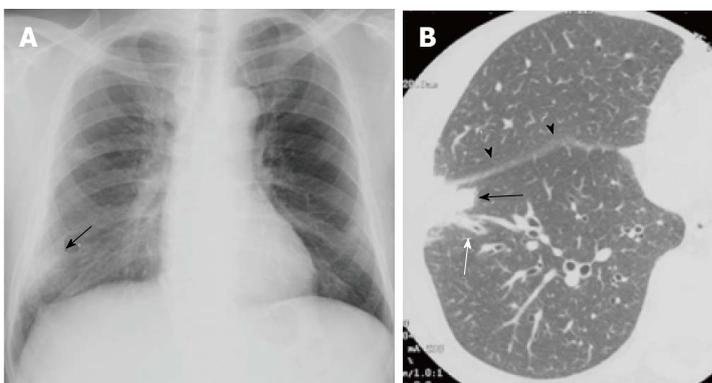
Chlamydomphila pneumoniae* pneumonia showing alveolar pneumonia in a man in his 60s. A: Chest radiograph shows an ill-defined consolidation at the right lower lung field (arrow); B: On thin-section CT, a subpleural focal consolidation is seen at the right S8 of the right lower lobe, partially extending into the middle lobe (black arrow). The interlobular fissure is mildly thickened (arrow heads). Mild bronchial wall thickening is also noted (white arrow). CT: Computed tomography.
